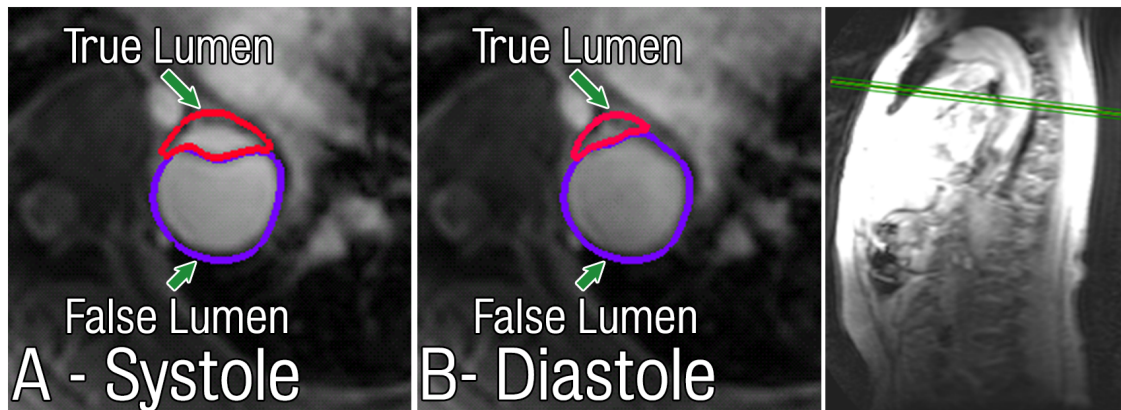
Primary patient specific study: 2D PC-MRI showing distention of the AD flap between peak systole (A) and mid-diastole (B).
